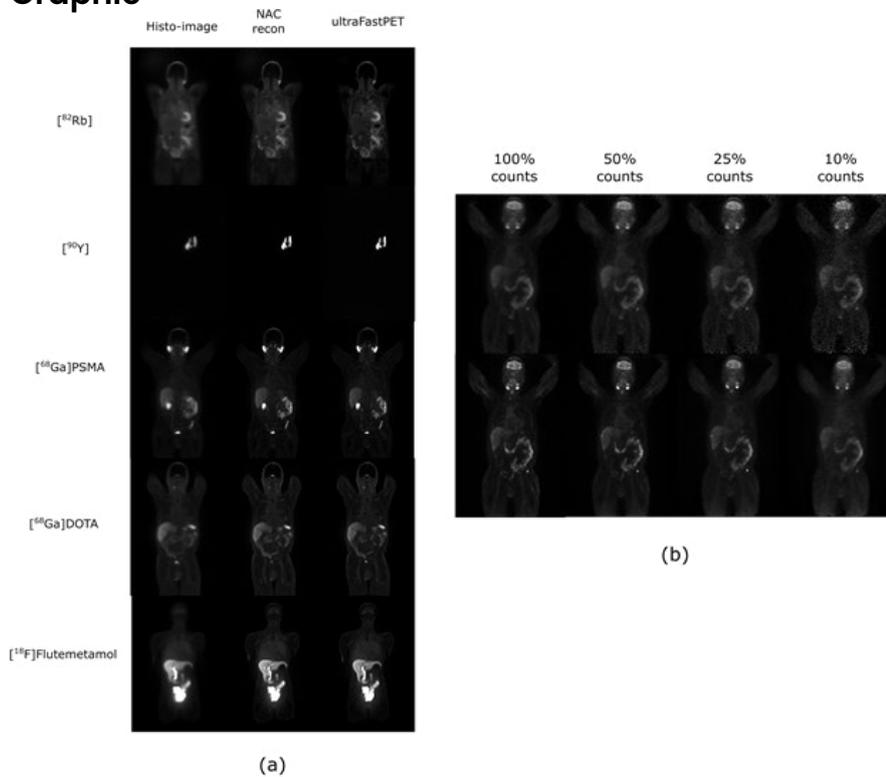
Generalizability of ultraFastPET. (a) Comparison of input histo-image vs. clinical NAC reconstruction vs. ultraFastPET output for different tracers. (b) Comparison of histo-images (top) vs ultraFastPET (bottom) for different count levels for an FDG acquisition.
